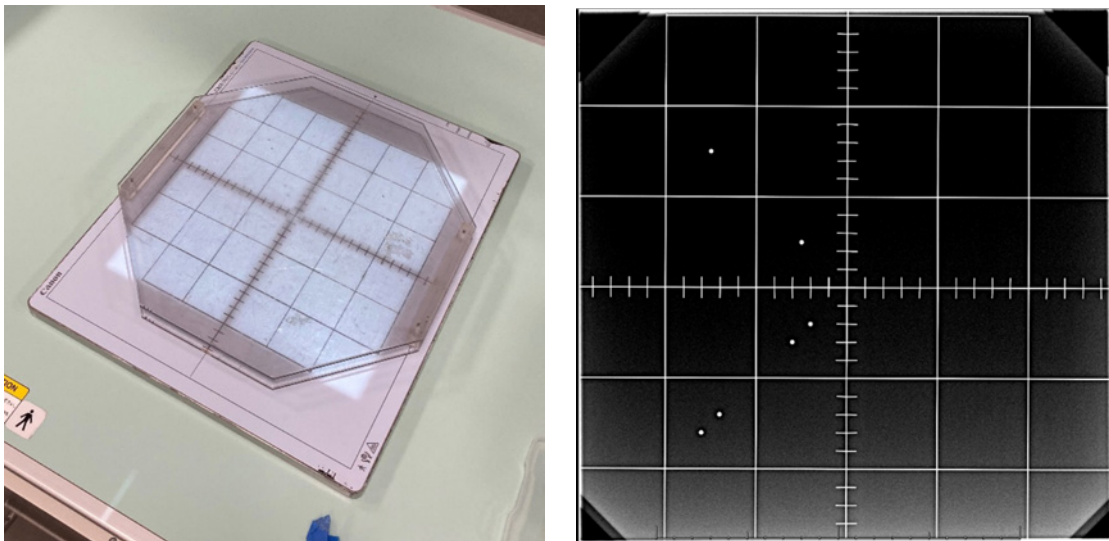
Measuring x-ray/light field alignment using grid of radio-opaque lines.
